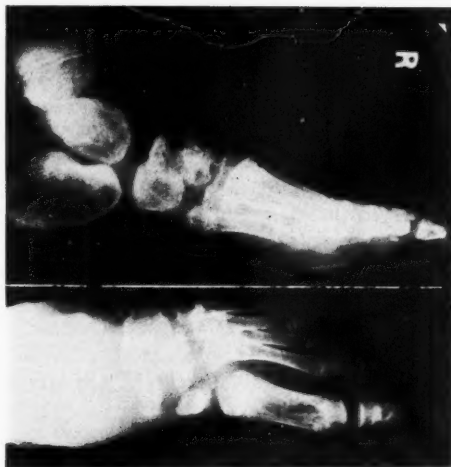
Roentgenogram of the foot. Note retarded tarsal development and double metatarsal epiphyses.
